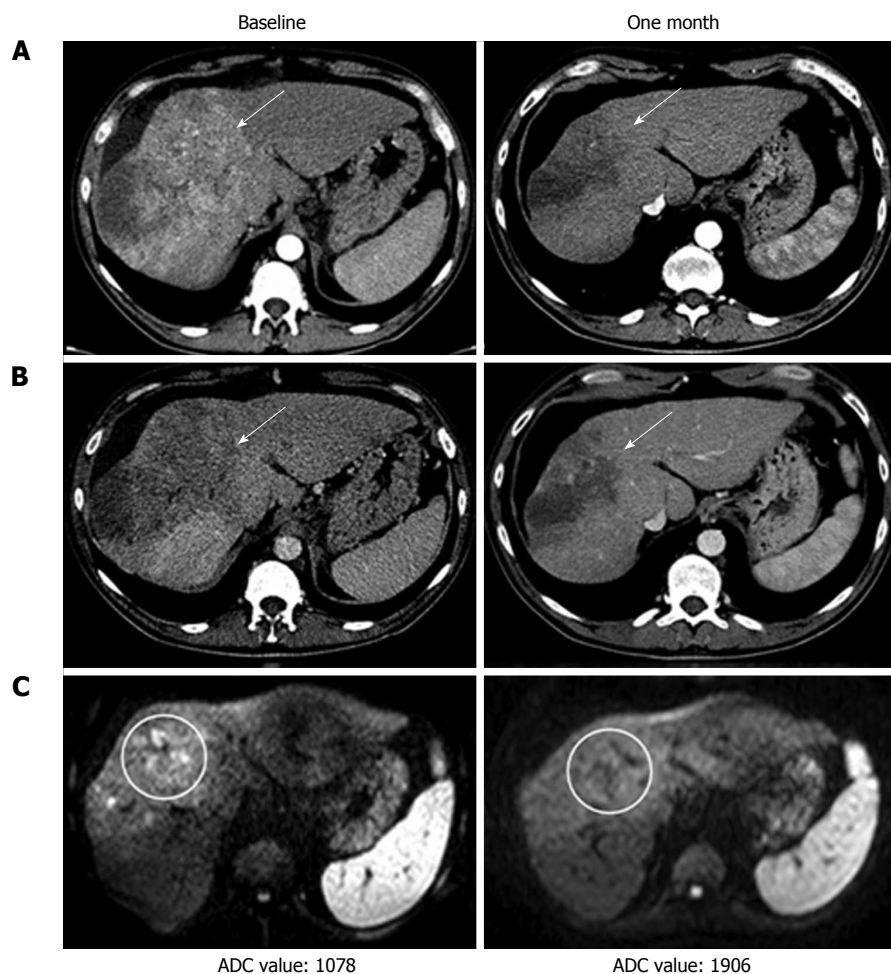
Computed tomography and magnetic resonance imaging examination at baseline and one month after the start of sorafenib therapy of a patient showing partial response. A: Arterial phase computed tomography (CT); B: Venous phase CT; C: Magnetic resonance imaging diffusion weighted imaging. ADC: Apparent diffusion coefficient.
